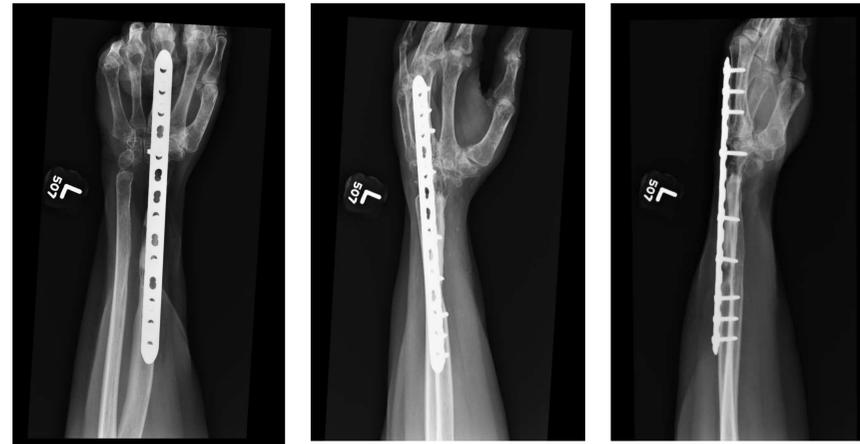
AP, oblique, and lateral radiographs of left wrist taken at 48 months follow up demonstrating incorporation of fibular allograft
